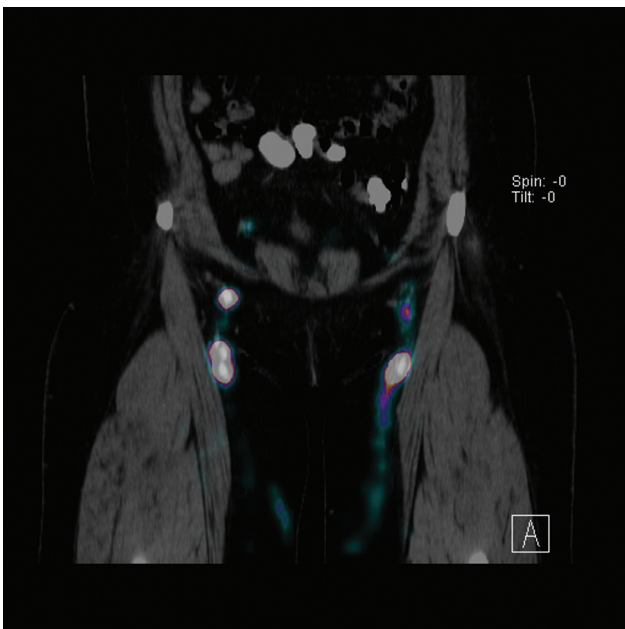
Lower extremity lymphoscintigraphy. Preoperative lymphoscintigraphy for mapping of the sentinel nodes draining the leg in preparation for harvest of the inguinal lymph nodes as a vascularized lymph node transfer (VLNT). Preoperative imaging is critical to
